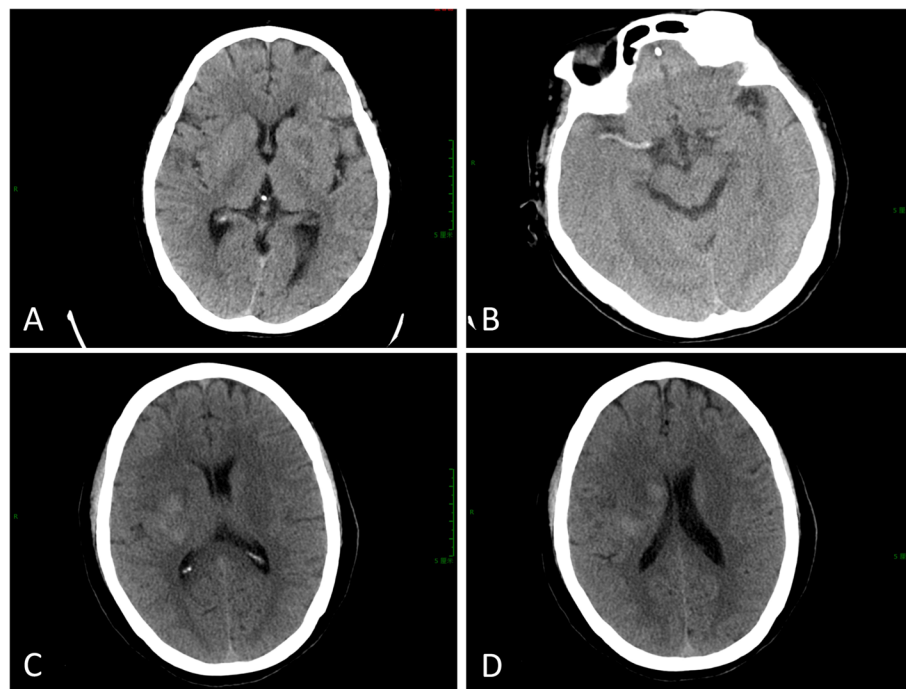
CT image analysis of patients with combined HT and non-HT. A and B CT images of patients without HT; C and D CT images of patients combined with HT
